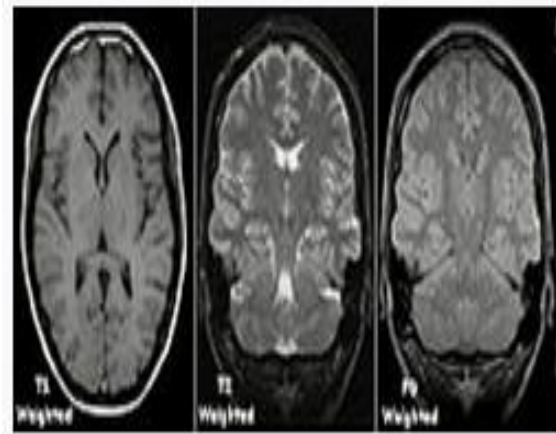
Example of T1 Weighted, T2 Weighted and PD Weighted MRI scans.
